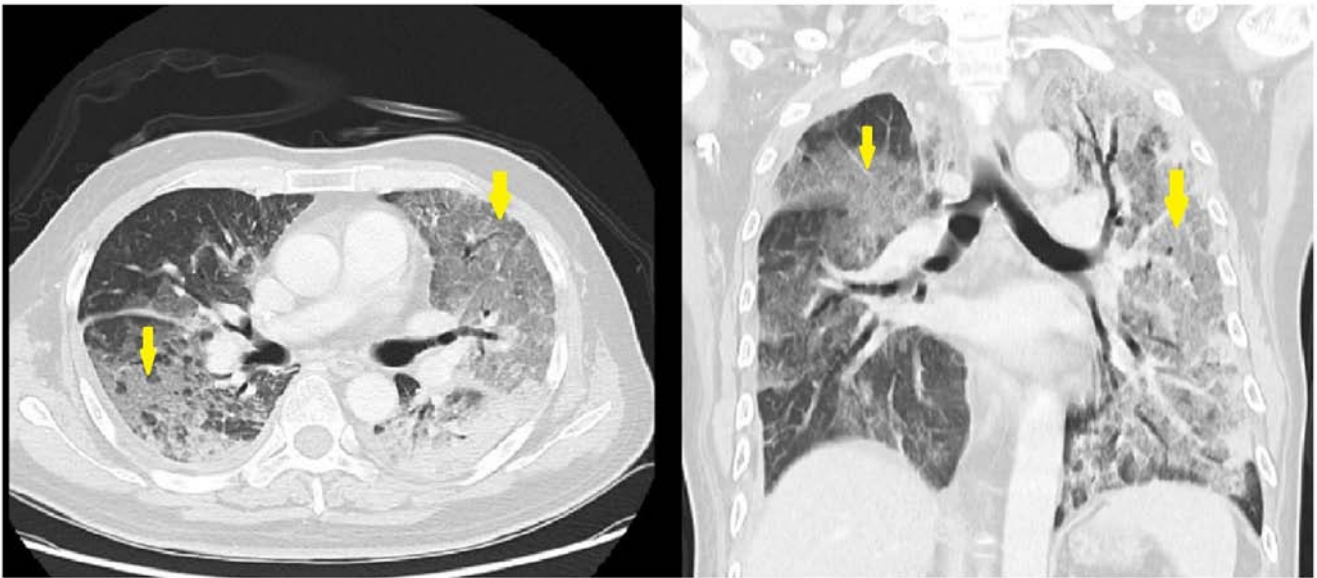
Chest computed tomography images. Extensive ground-glass opacity in both lungs and subpleural consolidation were observed (arrows), which was suspected to be drug-induced interstitial lung disease and pneumonia.
